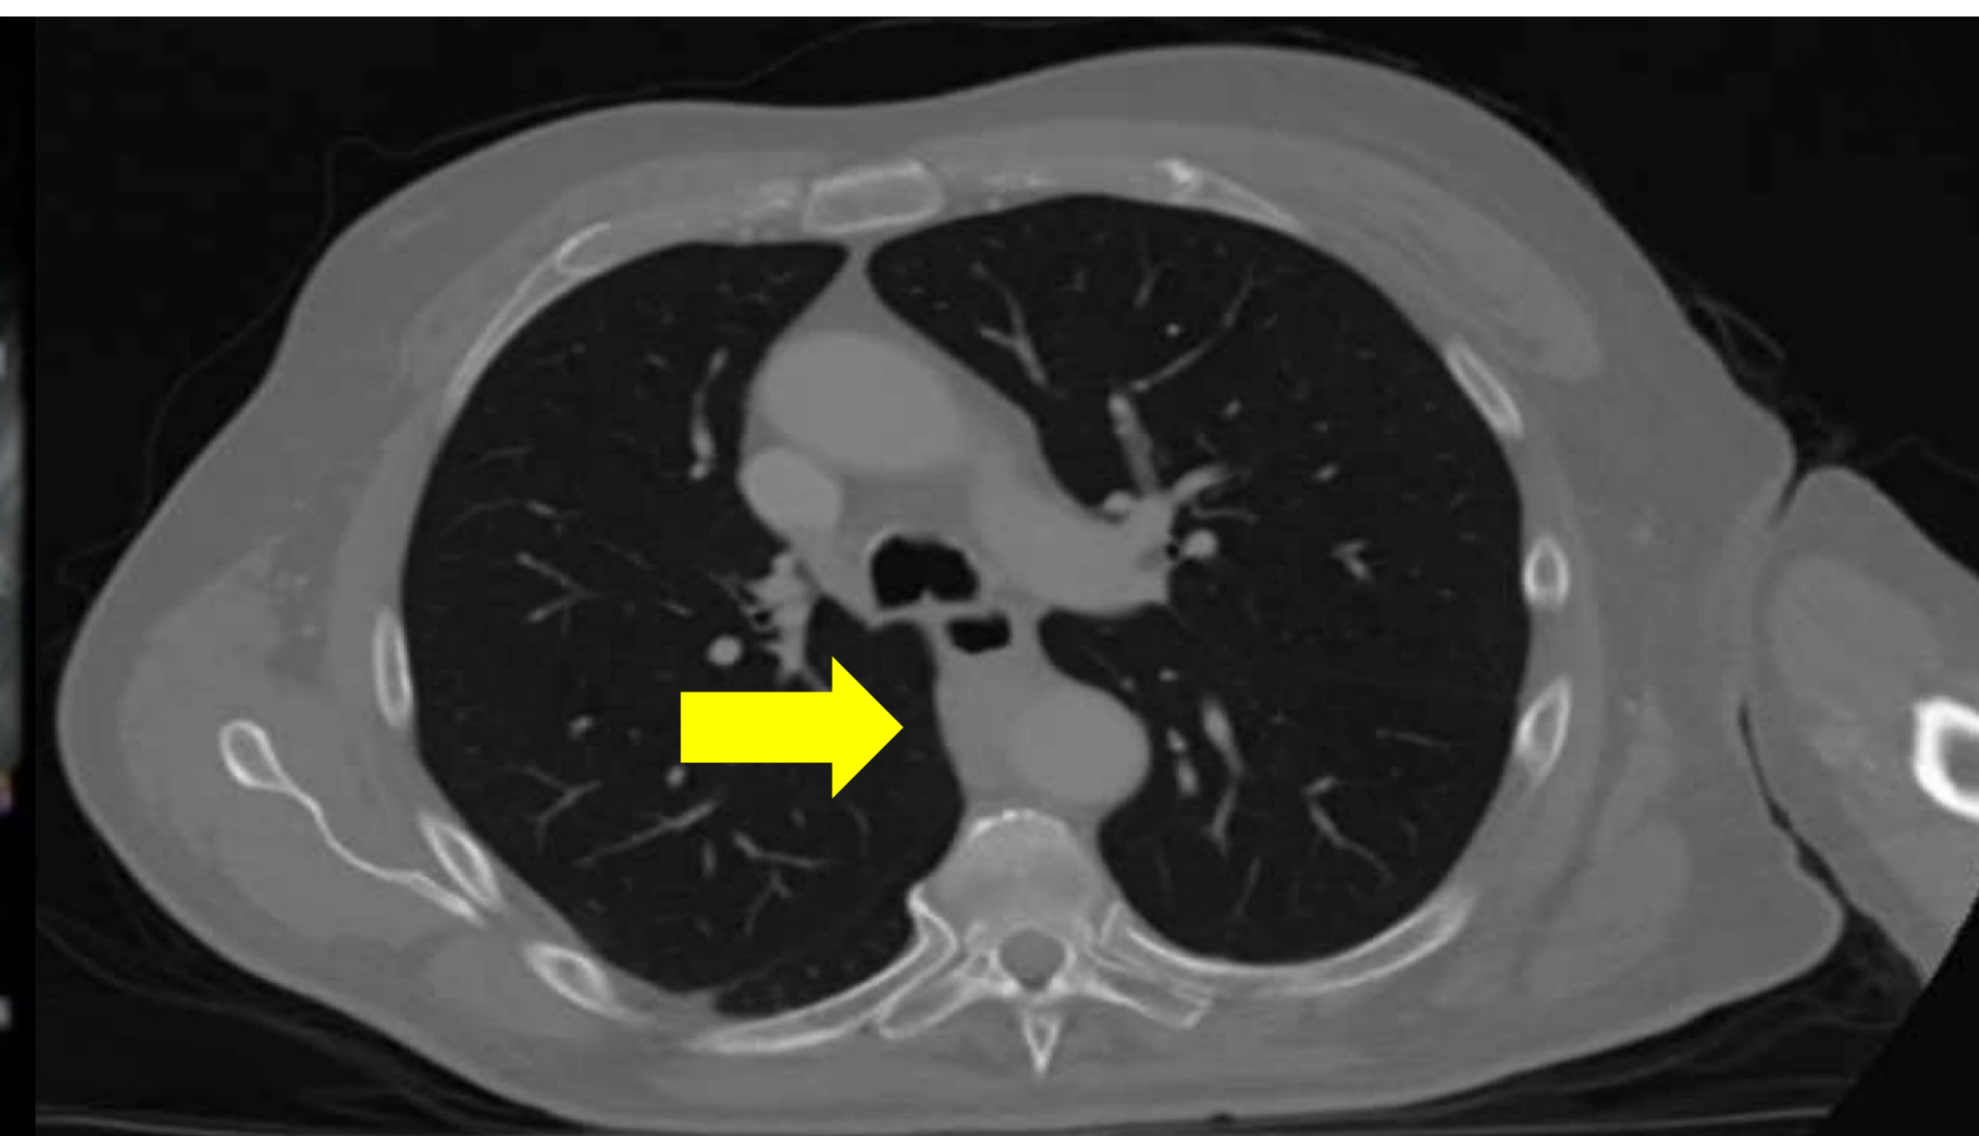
CT Chest showing circumferential mass posterior to the esophagus.
